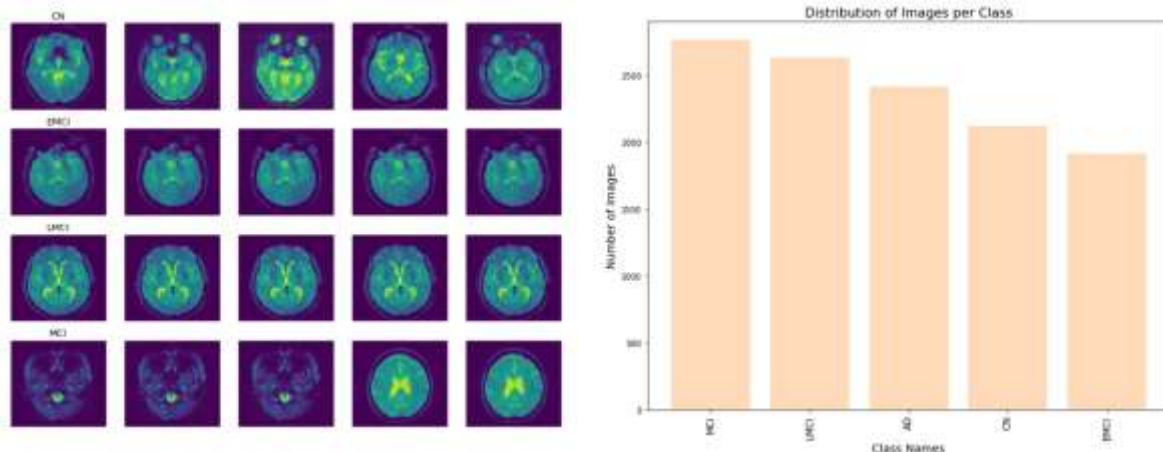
Dataset Exploration: Sample Brain MRI Images and Class Distribution in Alzheimer's Disease Dataset
